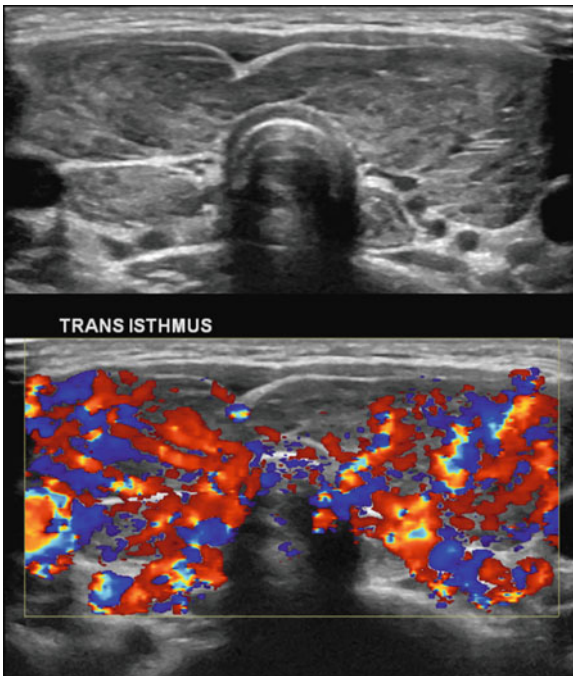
Thyromegaly and hyperemia. Grayscale and color Doppler US images demonstrate diffuse thyroid enlargement and typical findings of severe thyroiditis. Note the diffuse, but inhomogeneous, pattern of hyperemia.
